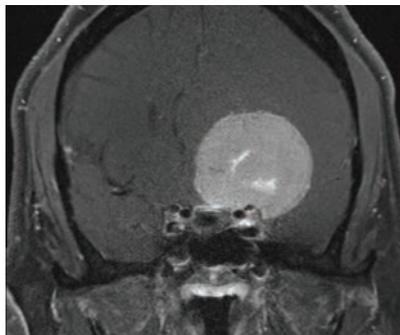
At left, the coronal view of the MRI. At right, the axial view of the MRI.
